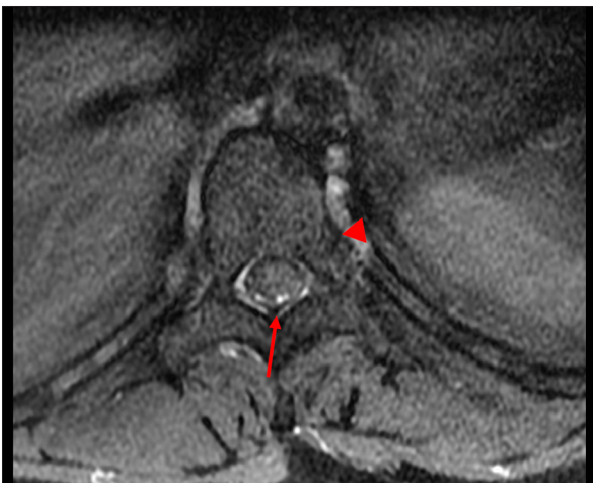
Post-contrast axial T1-weighted MRI image with fat suppression, showing the absence of enhancement of the intramedullary lesion, whereas enhancement is seen posterior to the spinal cord along the dilated prominent posterior epidural vessels (arrow) with a prominent perivertebral venous plexus (arrowhead).
